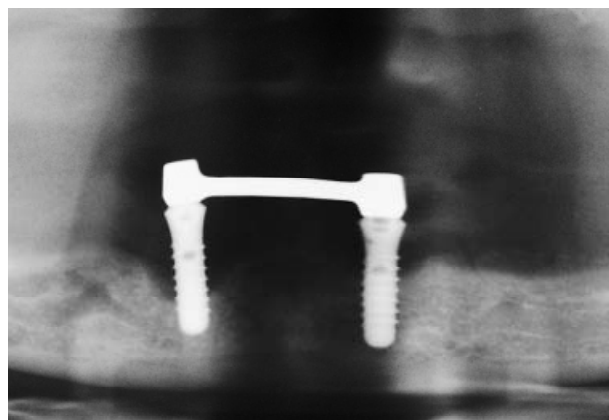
Preoperative X-ray of a peri-implantitis defect at regio 43 (case 1 from Table 1).
